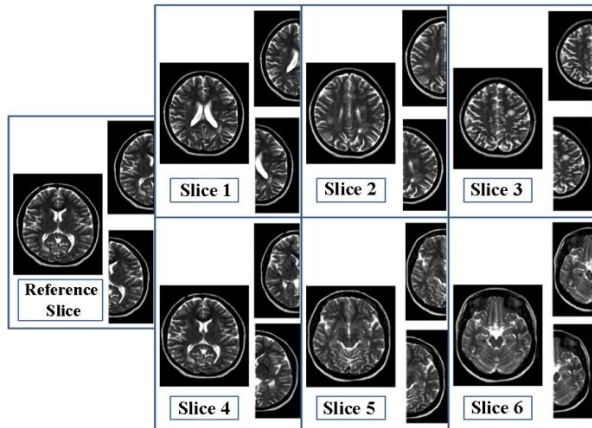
Samples of axial T2-W MRI slices of the brain and separation of the two hemispheres for a patient with MS
